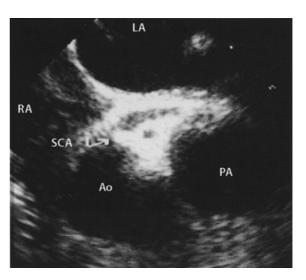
Anomalous coronary arteries: echocardiography. Echocardiography showing the single coronary artery origin (indicated by a white arrow) from the aorta (*Ao* aorta, *LA* left atrium, *PA* pulmonary artery, *RA* right atrium, *SCA* single coronary artery) (photograph courtesy of Dr. Nicole Sekarski)
